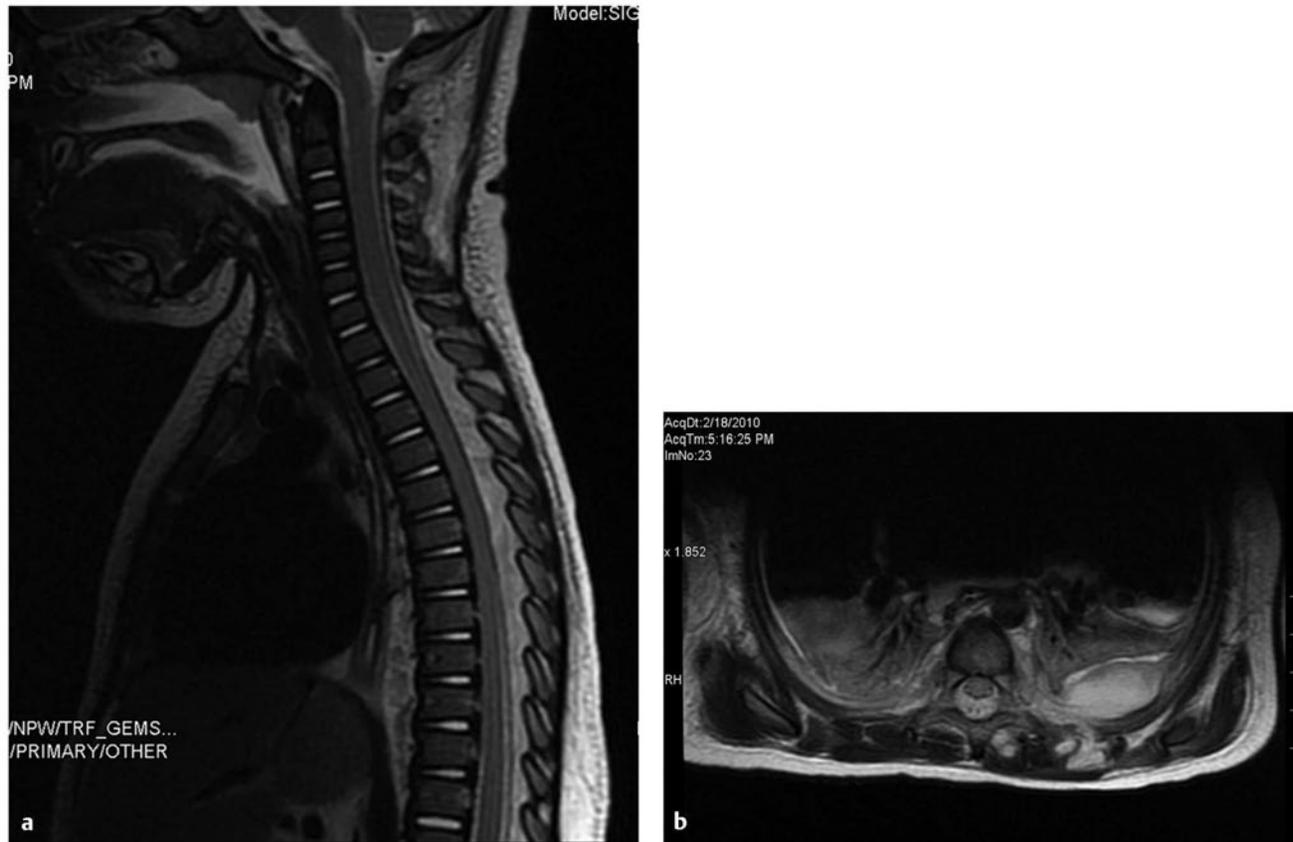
(a,b) Spinal epidural abscess. T2 fat-suppressed MRI images of the spine in a 13-month-old female with MRSA sepsis and positive CSF cultures. There is a faint, dorsal epidural fluid collection from T1 through T9 with enhancement, a left pleural effusion, and paraspinal abscess. The patient was treated with 3 level laminoplasty with irrigation and debridement. She remained neurologically intact and resolved without sequelae.
